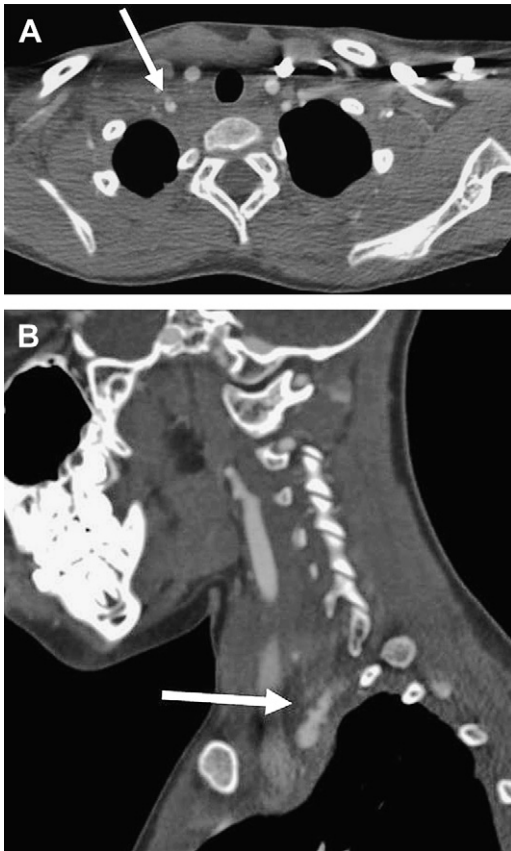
A 9-year-old boy after whiplash injury from a motor vehicle accident. (A) Axial and (B) sagittal CTA shows a dissection and intimal flap (arrow) of the proximal part of the right extracranial vertebral artery.
